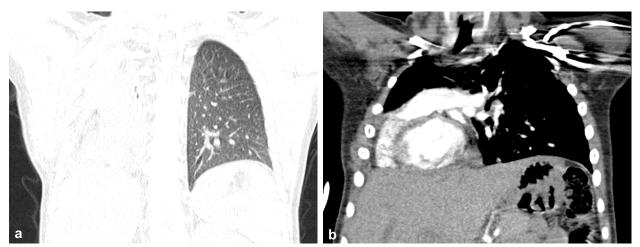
(a and b) Postoperative chest CT scan showed no signs of residual tumor with secondary hyperinflation of the left lung. CT: Computed tomography.
